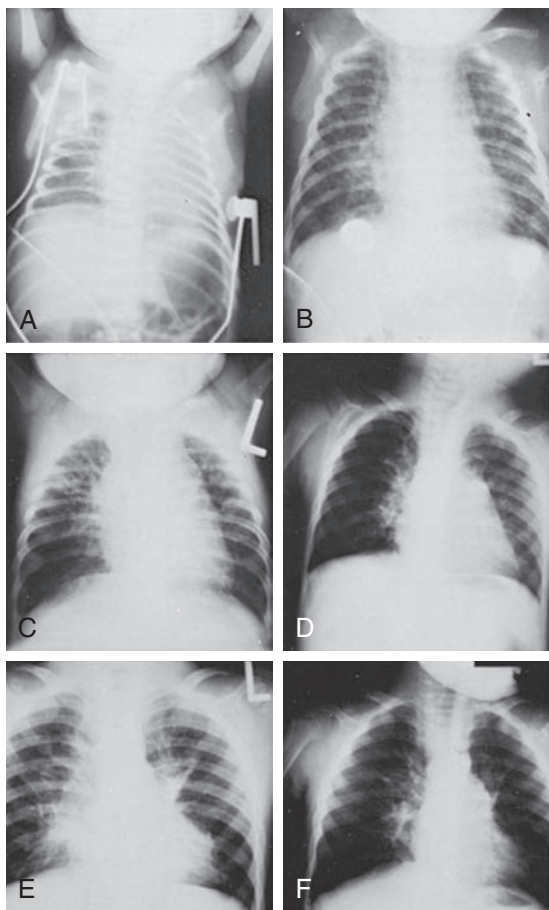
Serial chest x-ray films of premature infant with bronchopulmonary dysplasia over 2-year period. A, Newborn. B, Two months. C, Three months. D, One year. E, Two years. Infant's disease process was characterized by multiple hospitalizations for reactive airway disease and pulmonary hypertension. Note progressive lung disease characterized by hyperinflation and eventual clearing of infiltrate by 2 years of age (F).
